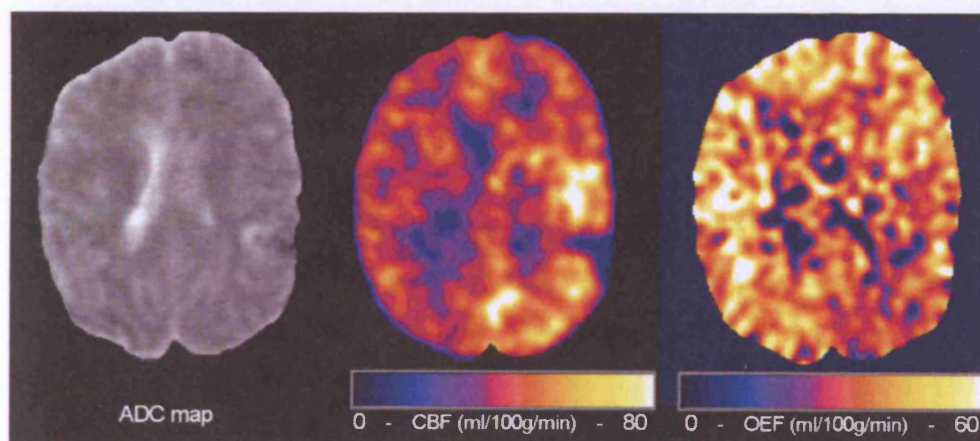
ADC map (left) showing left parietal contusion, CBF map (middle) with colour scale applied and OEF map (right) with colour scale applied. All images are coregistered to FLAIR.
